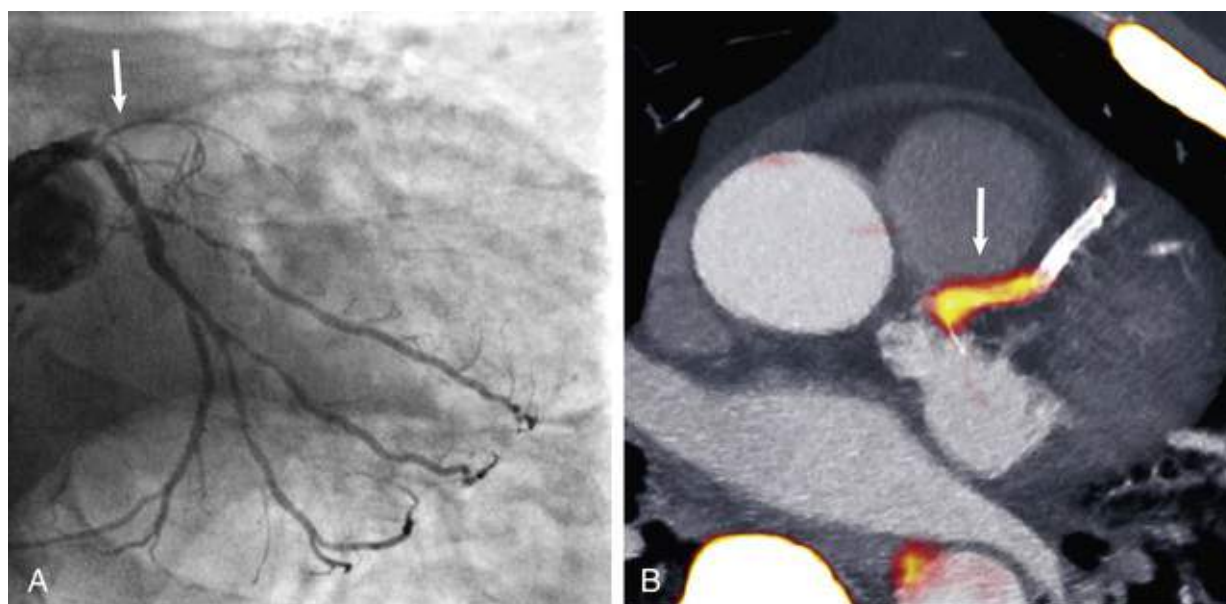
Uptake of ^{18}F -NaF in high-risk atherosclerotic plaque. A, Arrow indicates site of acute occlusion of proximal left anterior descending artery in patient with STEMI. B, PET-CT imaging performed several days later demonstrates intense focal uptake of tracer at plaque site (arrow), consistent with high-risk plaque features. (Modified from Joshi NV, Vesey AT, Williams MC, et al. ^{18}F -fluoride positron emission tomography for identification of ruptured and high-risk coronary atherosclerotic plaques: a prospective clinical trial. *Lancet* 2014;383:705.)
